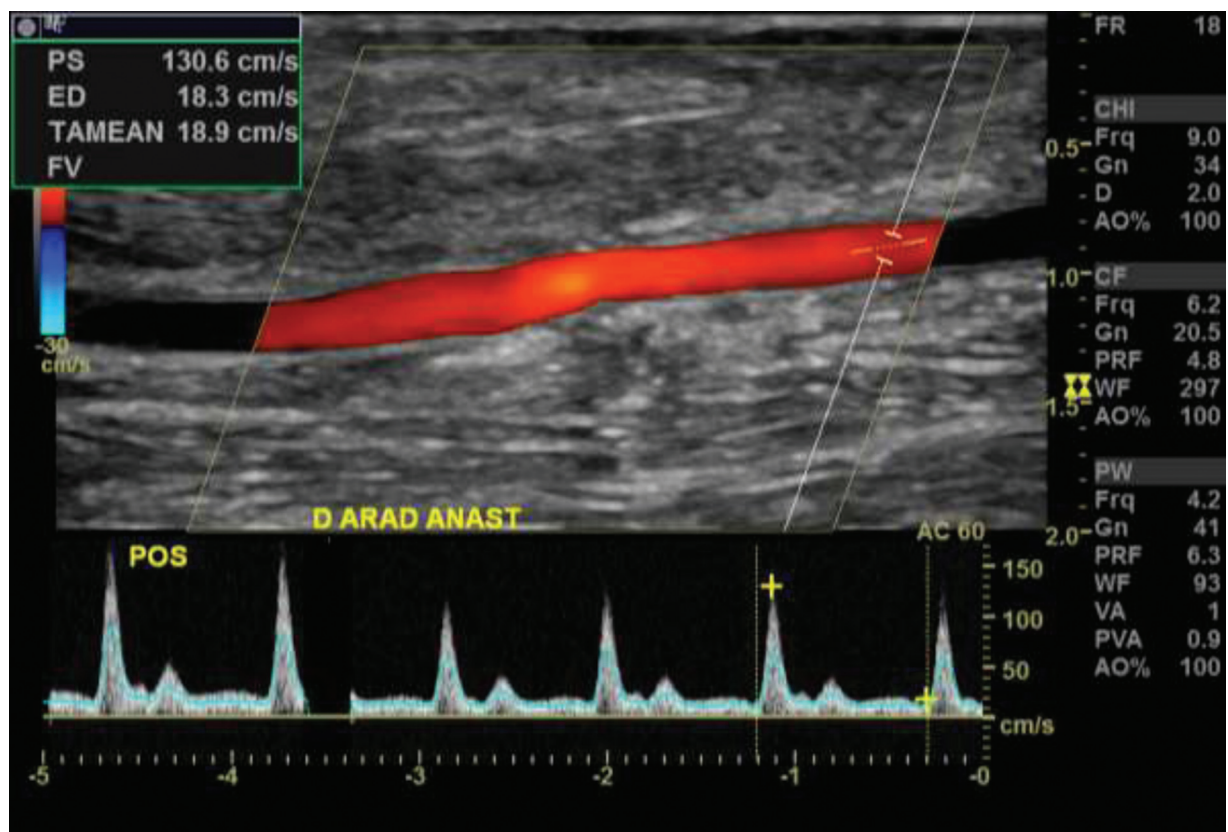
Doppler ultrasonography examination showing a patent artery after arteriorrhaphy.
